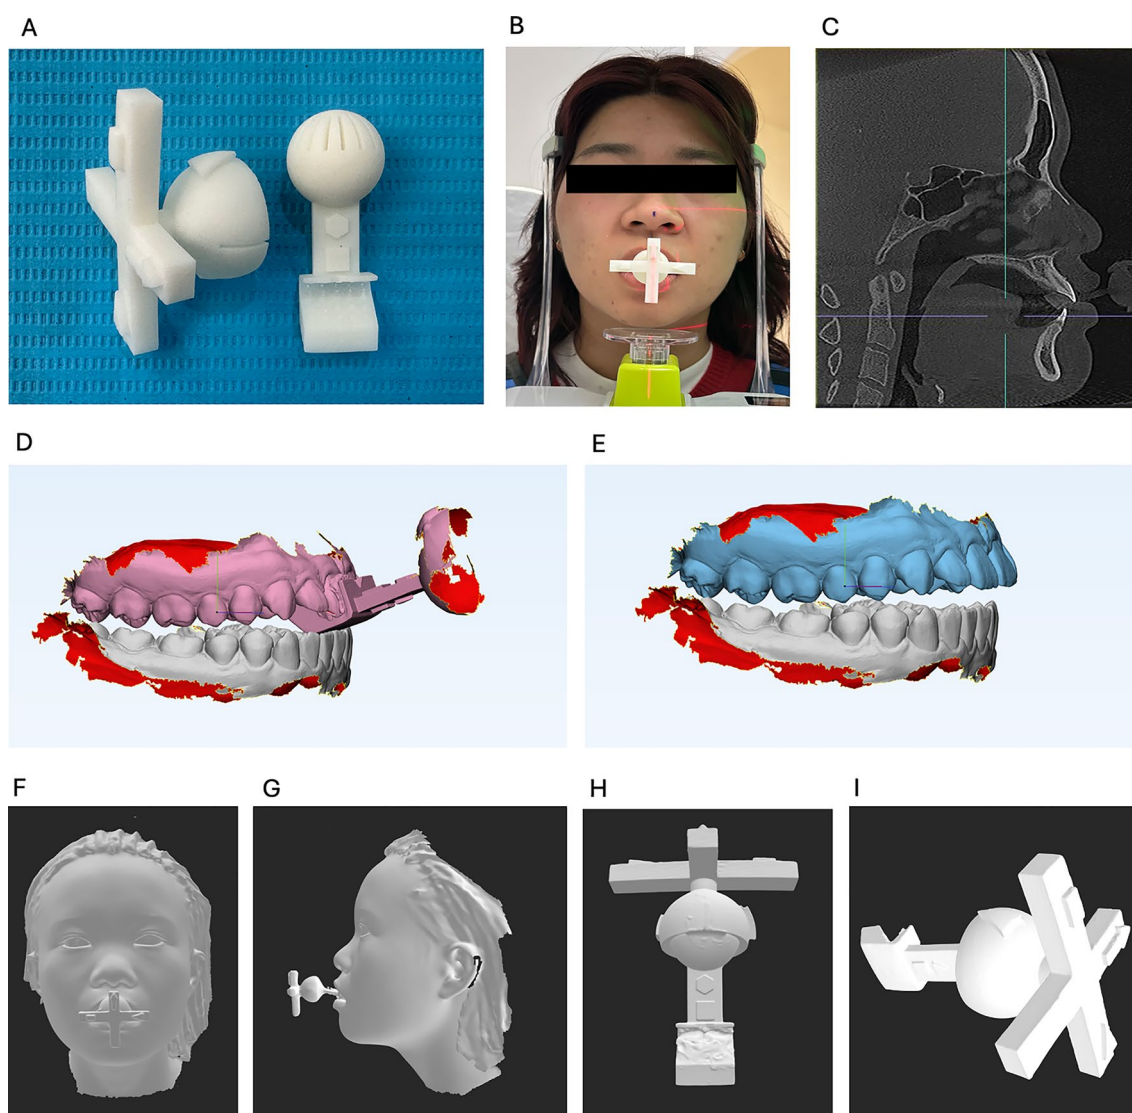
Study design. Twenty volunteers with class I occlusion underwent centric relation registration with a 3D-printed transfer key. After IOS and face scanning, the data were integrated and compared to the CBCT references
